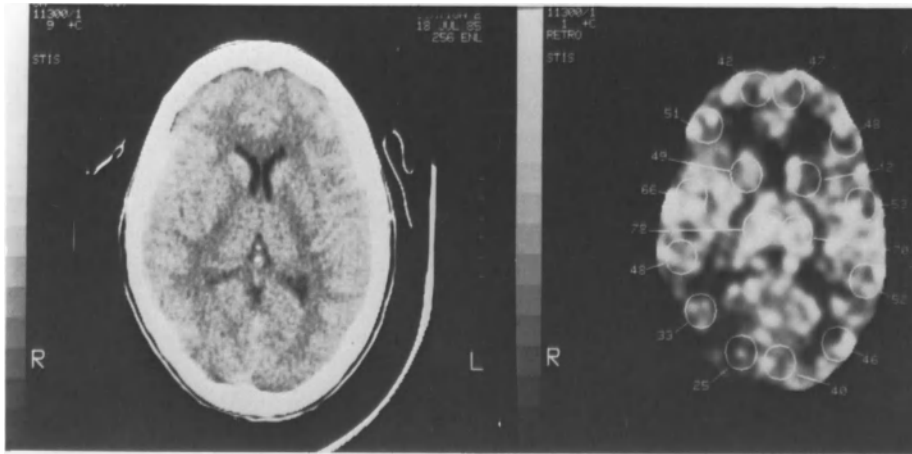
a. This is a relatively normal study with the baseline CT displayed on the left and its accompanying flow map on a gray scale of 0–100  $\text{cm}^3/100 \text{ g}/\text{minute}$  on the right. Two-centimeters-in-diameter ROIs have been placed on the flow image and the average flow value of each ROI displayed
